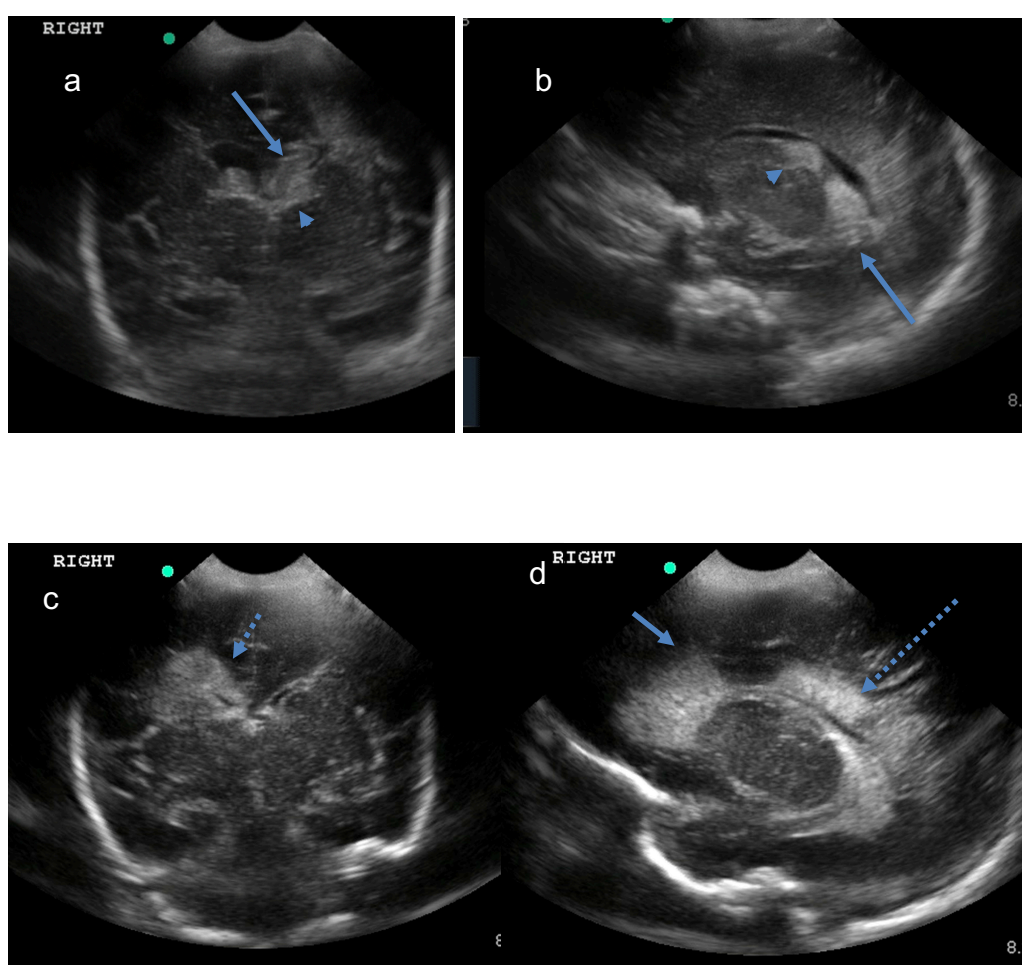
Cranial ultrasound scans showing a grade II haemorrhage with germinal matrix haemorrhage (arrowhead) and limited intraventricular haemorrhage (arrow) on a coronal image (a) and sagittal image (b). A Grade IV haemorrhage shown in a coronal (c) and sagittal (d) image with haemorrhagic infarction in the frontal (solid arrow) and parietal lobes (dotted arrow)
